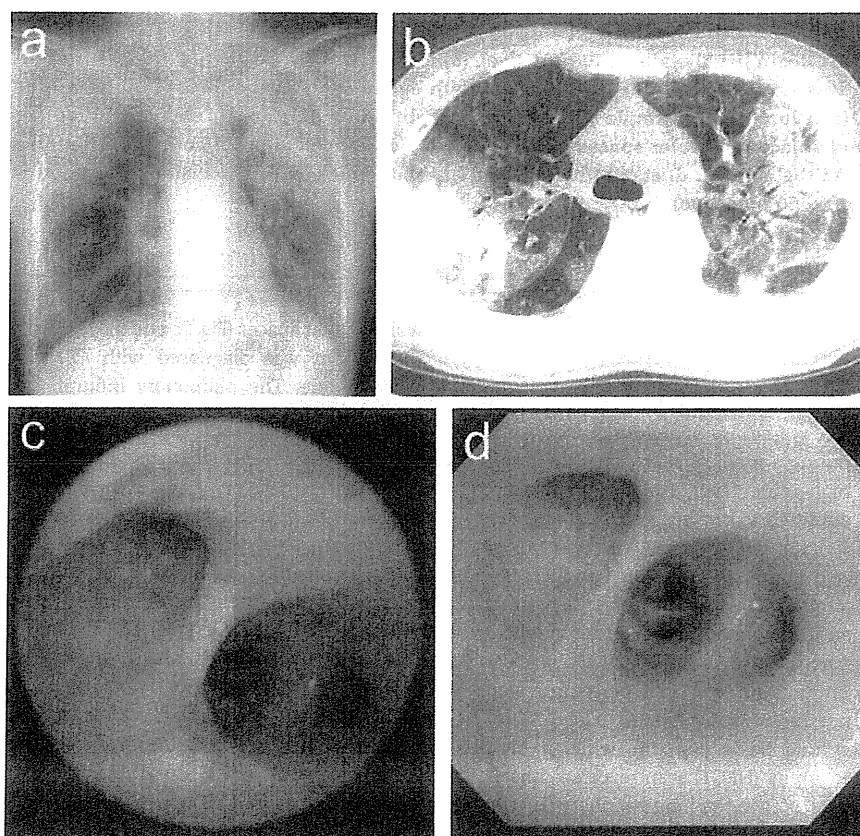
Radiological and bronchoscopic findings in Case 1. (a) Chest radiograph at admission showing bilateral consolidations in the upper and middle lung fields. (b) Computed tomography of the chest at admission showing bilateral consolidations in the relative periphery of the lungs. (c) Multiple whitish nodules on the right middle and inferior bronchial mucosa, as revealed by fiberoptic bronchoscopy 4 days after admission. (d) Disappearance of the tracheobronchial nodules 40 days after steroid therapy began.
